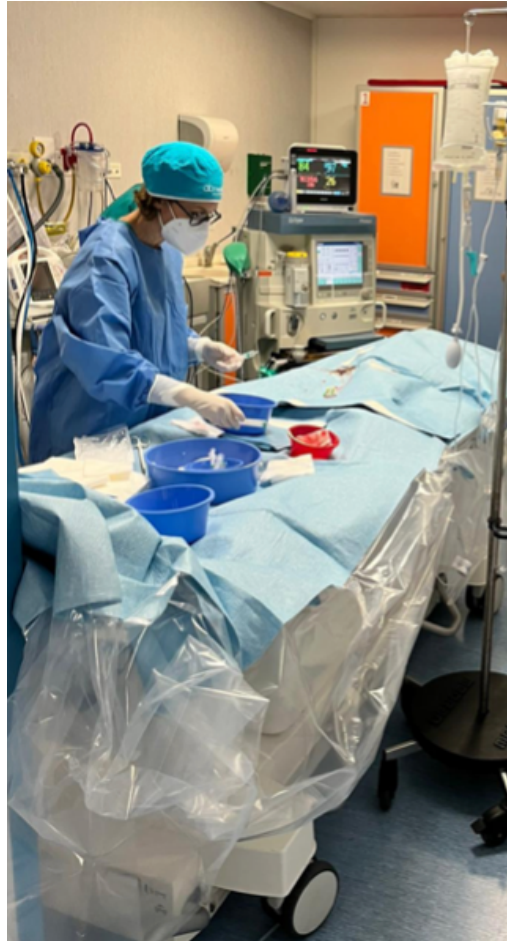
CMR room. The MRI-compatible detachable table is moved to the MRI scanner. The MRI scanner side is draped with sterile surgical drapes to avoid any contamination. Our CMR suite contains MRI-conditional anaesthesia equipment, ventilators, infusion pumps and patient monitors, haemodynamic recording system, and a CMR-compatible monitor to mirror the scanner display for in-room catheter visualization.
